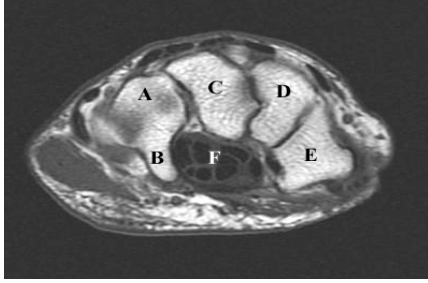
T1-weighted axial of wrist through distal carpals. A-hamate, B-hook of hamate, C-capitate, D-trapezoid, E-trapezium, F-flexor tendons in carpal tunnel
